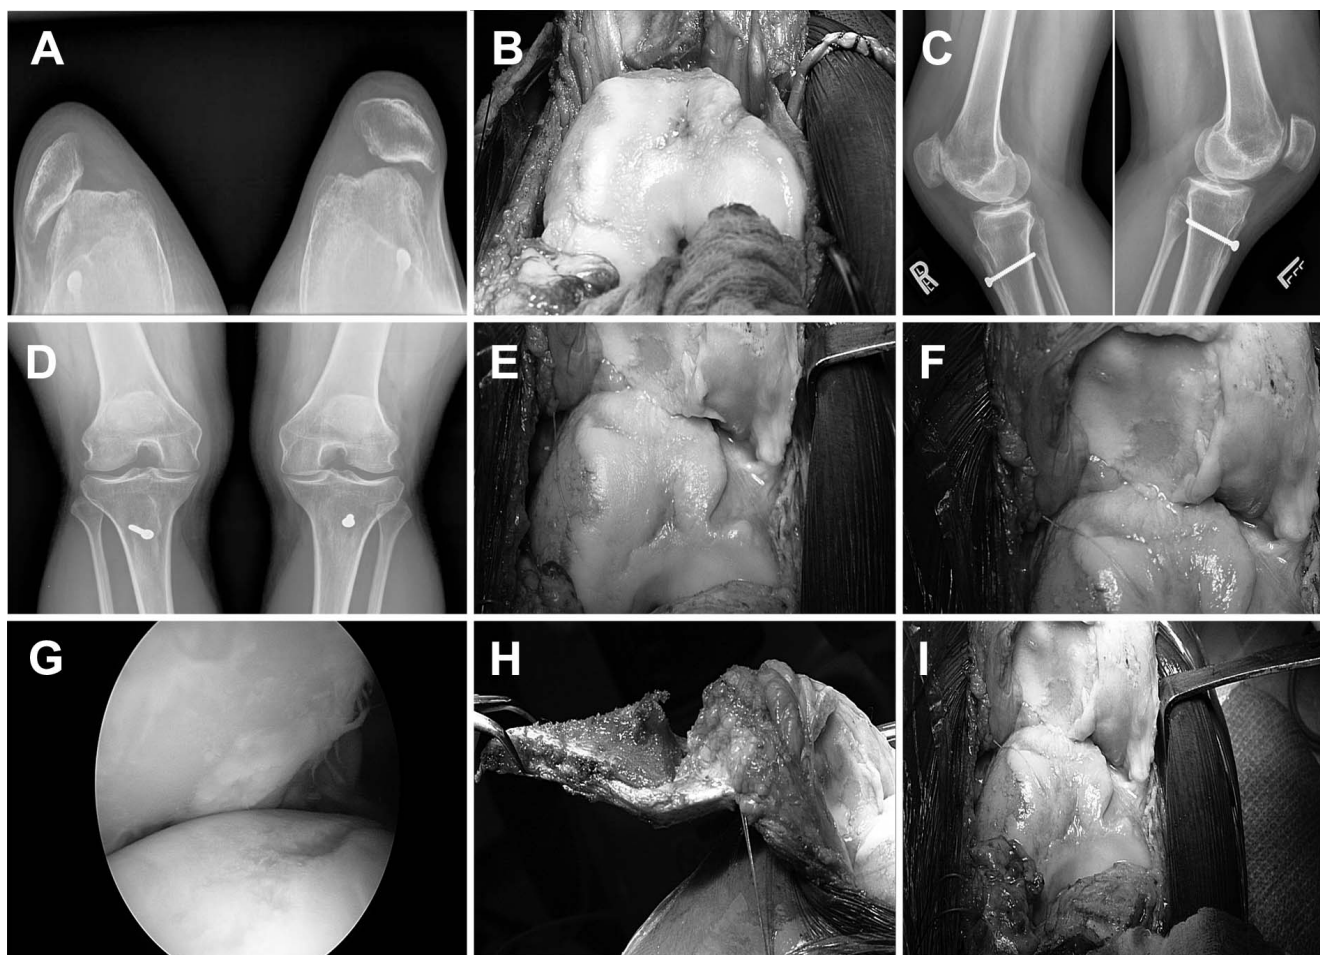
A: Merchant view x-rays of bilateral knees demonstrate the dislocated right patella and subluxated left patella. B: Severe trochlear groove dysplasia with chondromalacia. C: Bilateral Rosenberg view x-ray demonstrates the previous tibial tubercle osteotomy (TTO). D: Bilateral lateral view x-ray demonstrates the previous TTO. E: High-grade chondromalacia of the trochlear groove along with severe dysplasia. F: High-grade chondromalacia of both patellar facets. G: Arthroscopic view from the anterior medial portal demonstrates the dislocated patella with high-grade chondromalacia. H: TTO everted 360° to access the knee joint. I: Full access to the knee joint after 360° patella eversion.
